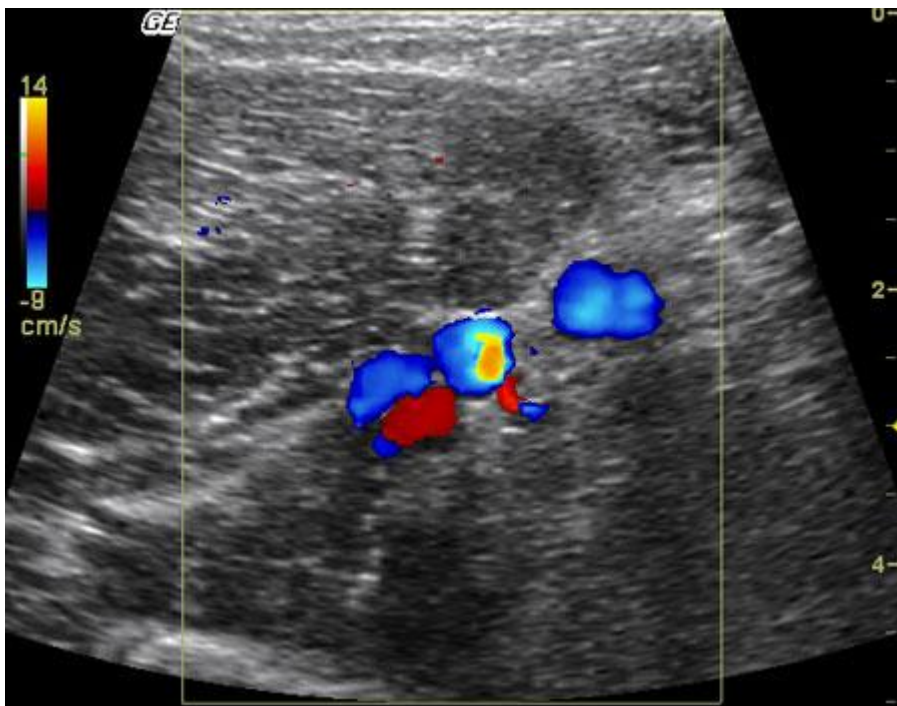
Color Doppler imaging can also be used to confirm patency of the vein segments that can also be compressed. Such images are reassuring of the absence of any thrombus. The brachial artery sits in between both brachial veins, as shown on this image.
